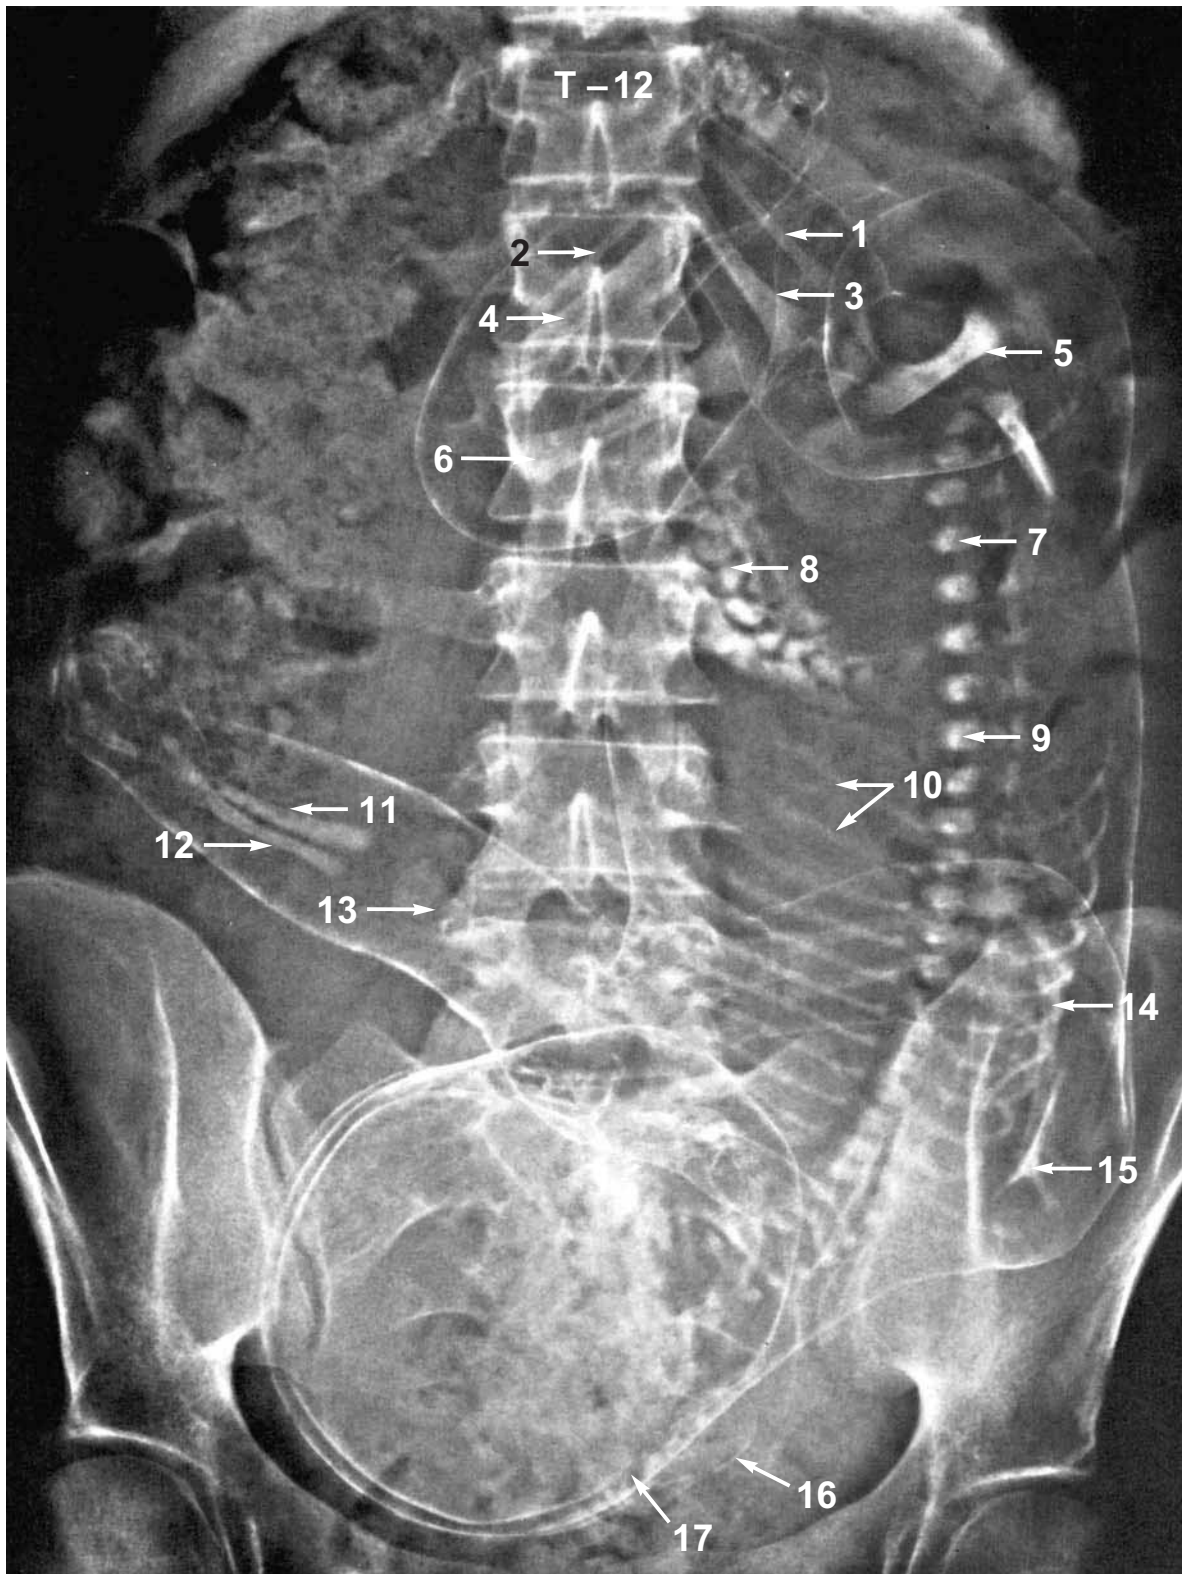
Fetal Roentgenogram
